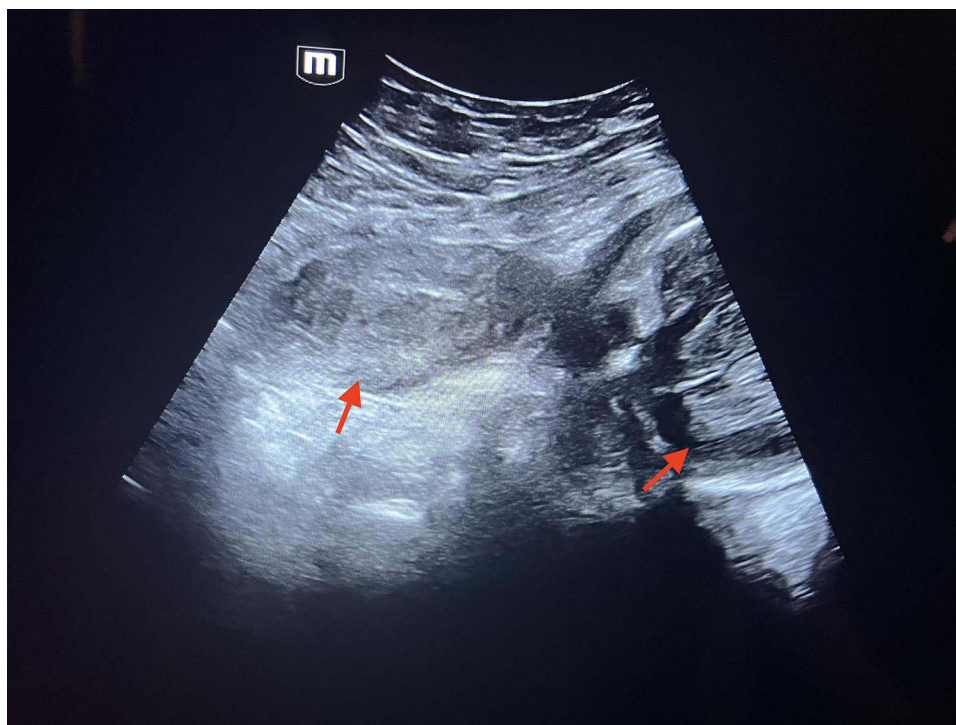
Transabdominal ultrasound showing two adjacent noncommunicating uteri (arrows), one of which is empty and the other is bearing a fetus.
